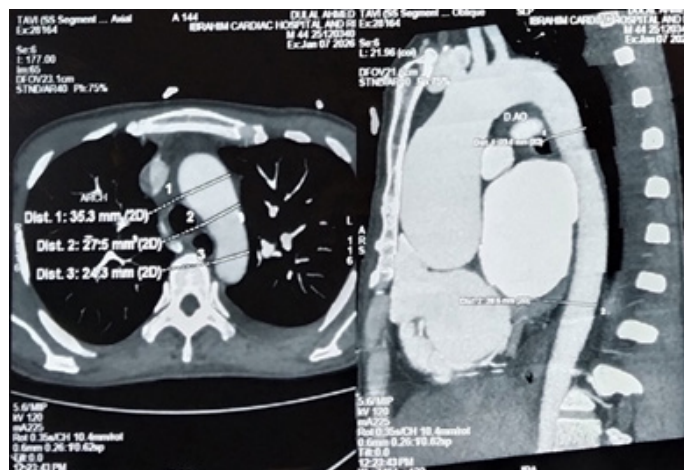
The CTA of the aorta showed the dilatation of tubular ascending aorta.
